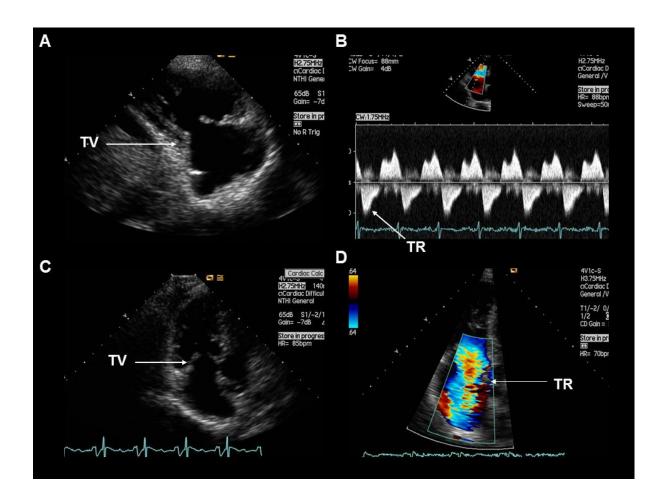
Carcinoid Involvement of Tricuspid Valve (TV) A. Right ventricular inflow view. Fixed, retracted and thickening of tricuspid valve leaflets and associated chordae. B. Continuous wave Doppler showing "dagger shaped" profile of tricuspid regurgitation (TR). C. Apical 4 chamber view showing dilated right ventricle with tricuspid valve leaflets failing to co-apt resulting in constant "semi-open" position. D. Colour Doppler demonstrating severe tricuspid regurgitation into a dilated right atrium.
